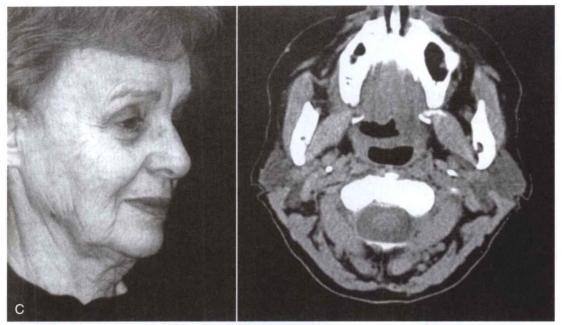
cont'd C, CT scan showing the facial anatomy of a 75-year-old female. (From Faerber TH: Evaluation of the aging face. In Niamtu J (ed): Cosmetic facial surgery. Oral Maxillofac Surg Clin North Am, pp 523–530, 2000.)
